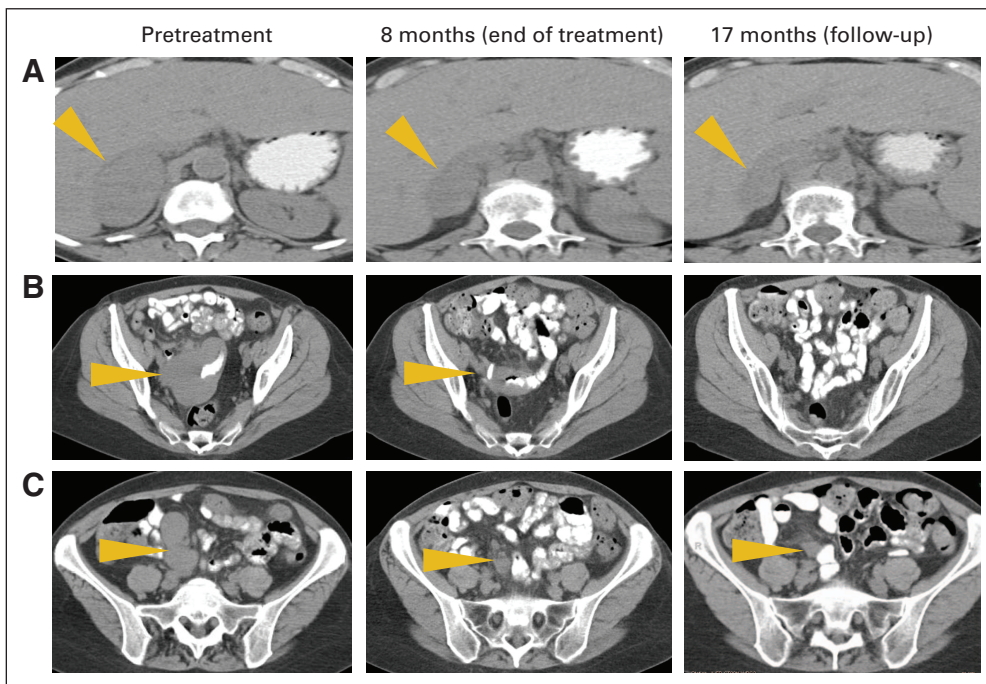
Partial response of metastatic melanoma to nivolumab, with continued tumor regression after drug discontinuation. This 59-year-old woman previously had experienced disease progression following high-dose interleukin-2, temozolomide, and sorafenib therapies. She received nivolumab 10 mg/kg every 2 weeks and achieved a partial tumor regression at 2 months. Treatment was discontinued at 8 months (four treatment cycles) as a result of exacerbation of an upper extremity neuropathy. Tumor regression continued after drug discontinuation. Computed tomographic scanning was performed with oral contrast but without intravenous contrast dye. Gold arrows indicate melanoma metastases involving (A) the right adrenal gland, (B) small bowel, and (C) mesenteric lymph nodes.
